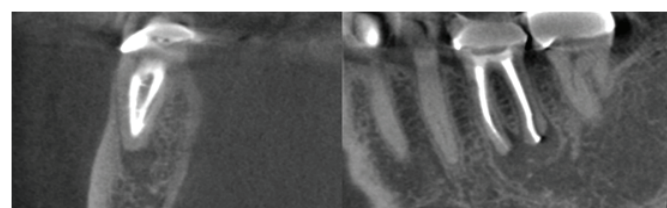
Pre-Procedure Radiograph Showing the Previously Placed Silver Points
